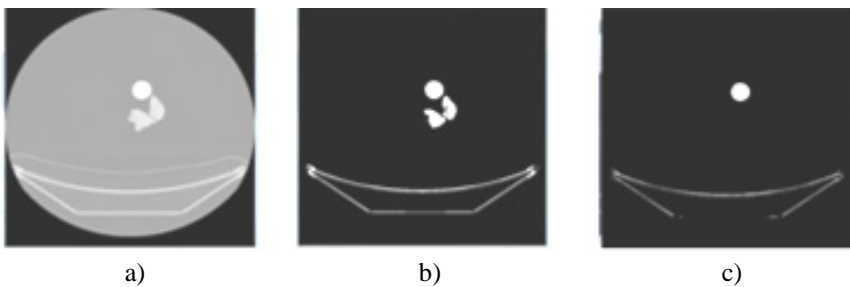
a) original CT, b) 0.72 threshold value, c) 0.76 threshold value.
